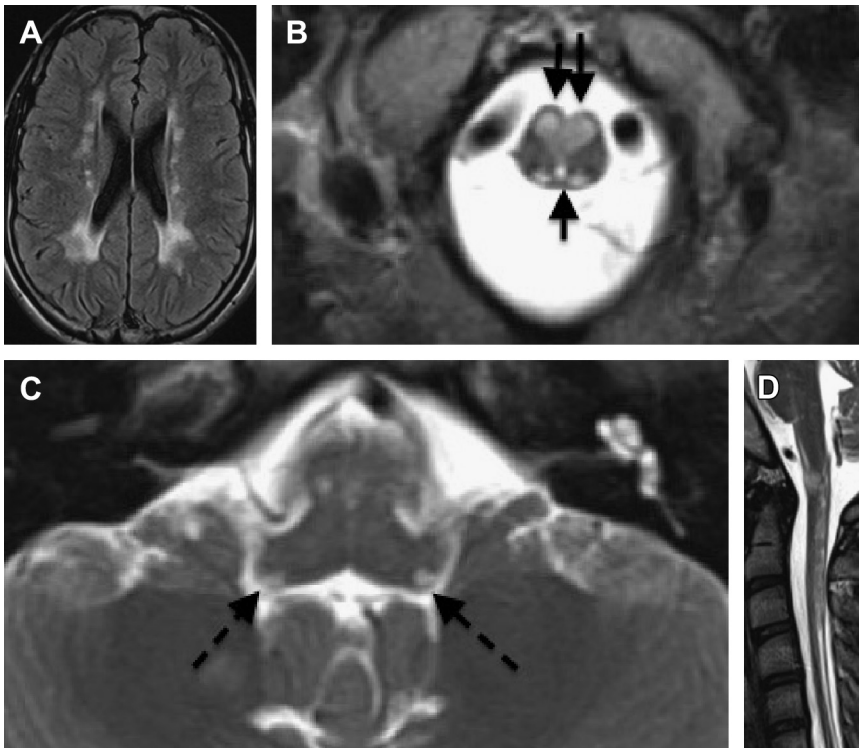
Seventeen-year-old girl with leukoencephalopathy with brainstem and spinal cord involvement and increased lactate. Axial FLAIR image (A) demonstrates patchy central white matter signal increase. Axial T2-weighted images (B, C) demonstrate abnormal signal in the dorsal columns (*single arrow*), medullary pyramids (*double arrow*), and inferior cerebellar peduncle (*dashed arrows*). Dorsal column involvement is also visible on the sagittal T2 image of the cervical spine (D).
